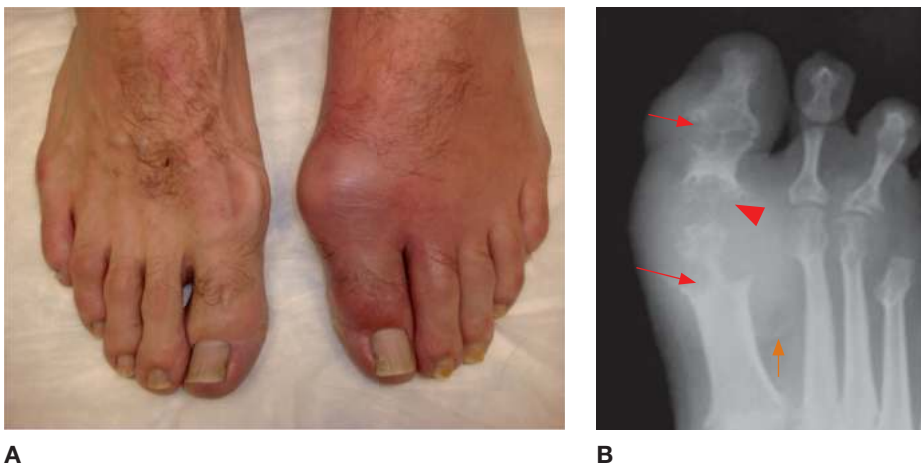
Gout. (A) A swollen left first MTP joint with overlying erythema and warmth, characteristic of an acute gout attack (podagra). (B) AP radiograph of the right foot in a different patient showing the severe consequences of long-standing gout, including large, nonmarginal erosions with overhanging edges of bone (*red arrows*), soft tissue swelling, and destruction of the first MTP joint (*arrowhead*). Note the subtle calcification of a gouty tophus (*orange arrow*). (Image A reproduced with permission from LeBlond RF et al. *DeGowin's Diagnostic Examination*, 9th ed. New York: McGraw-Hill, 2009, Plate 30. Image B reproduced with permission from USMLE-Rx.com.)
